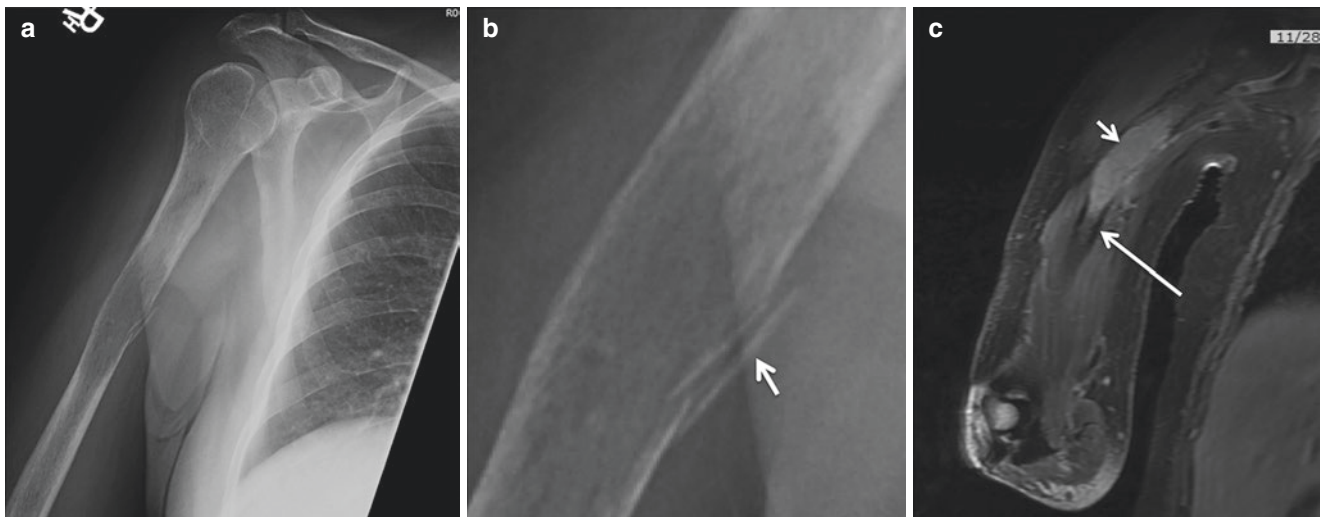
AP radiograph of the humerus demonstrates a geographic, moth-eaten, lytic, destructive lesion, with cortical endosteal thinning and mild marrow cavity expansion (a). (b) Magnified image of the associated pathologic fracture with adjacent cortical fragments (arrows). Coronal T1 postcontrast fat-saturated MR image (c) demonstrates
